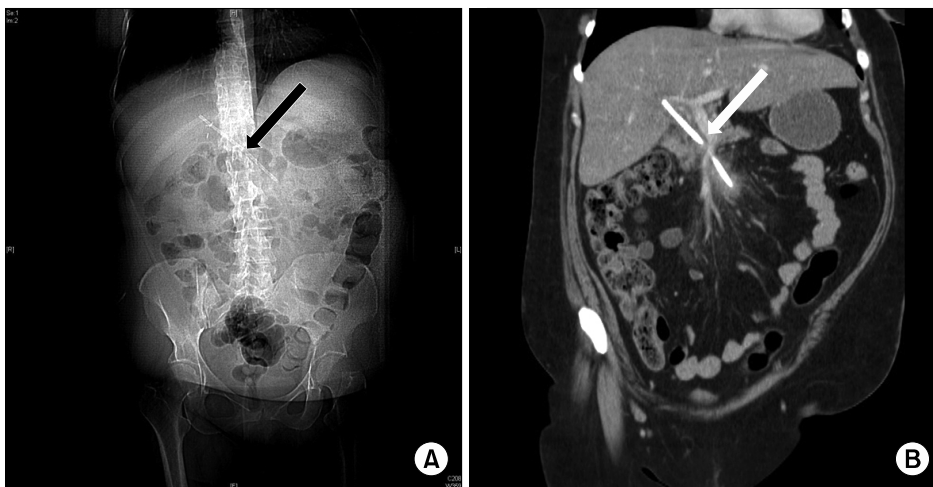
X-ray and CT-scan. Imaging showing no abnormality regarding the abdominal X-ray (A) but a malpositioned biliary stent at abdominal CT-scan (B). The white arrow shows the biliary stent.
